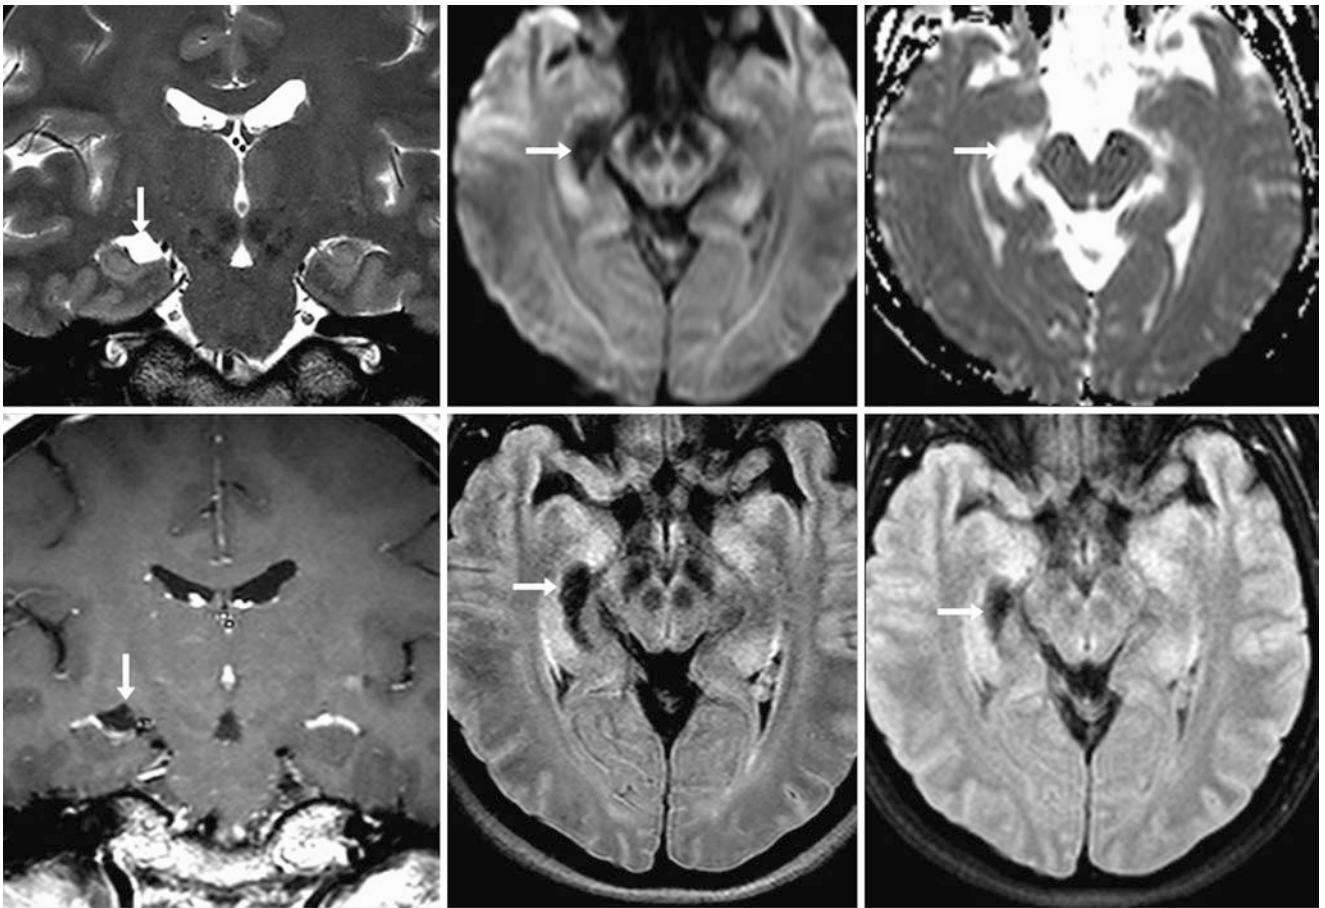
A 46-year-old female underwent a 3 T MRI performed for seizures that shows prominence of the right choroidal fissure representing a CFC (arrows), as shown on a coronal T2WI (left), axial DWI (top middle), ADC maps (top right), and postcontrast coronal T1WI (bottom
